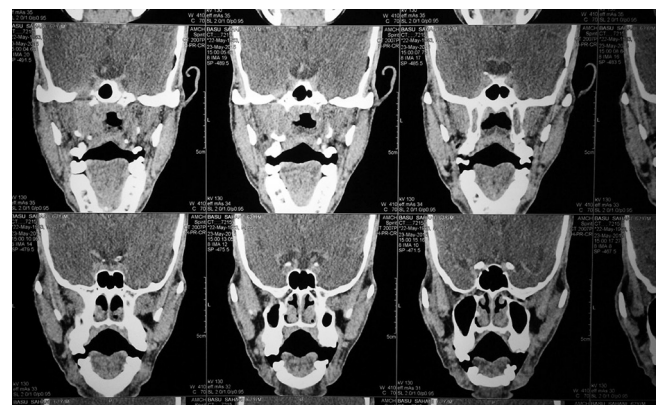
CT Scan of head and neck
